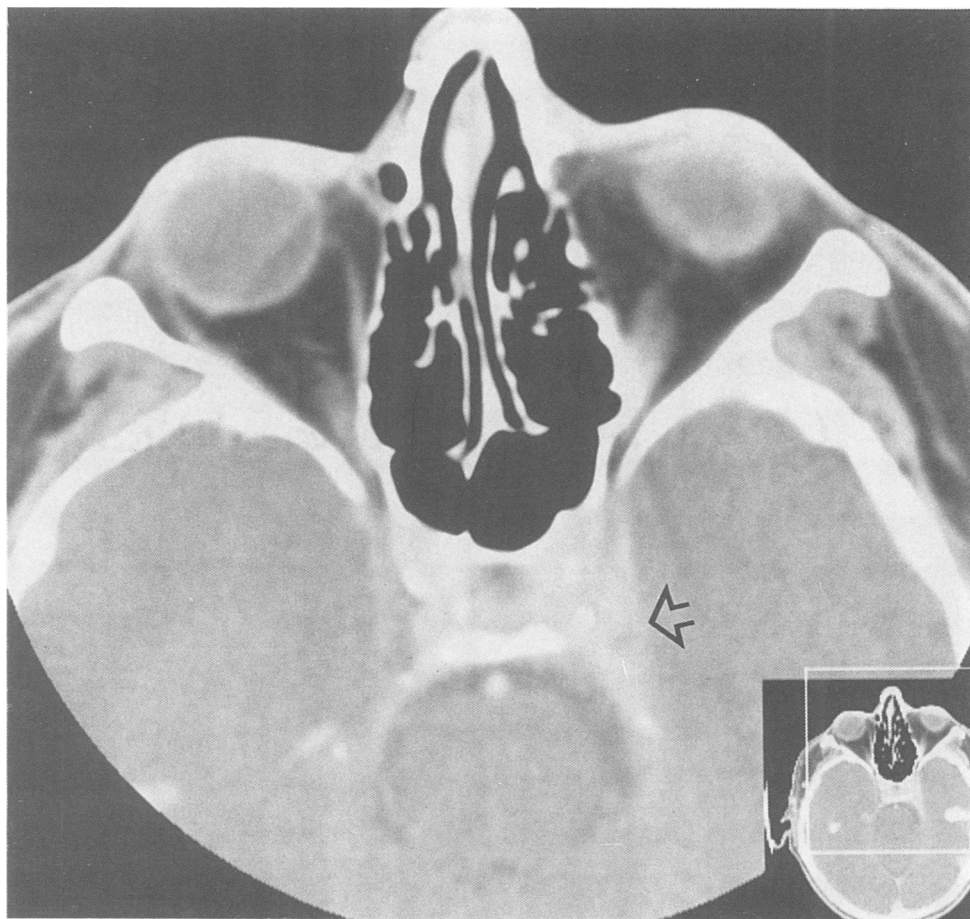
A cerebral CT scan with intravenous contrast showing an enlarged view of the orbit. A contrast-enhancing lesion is demonstrated against the medial wall of the left cavernous sinus.
